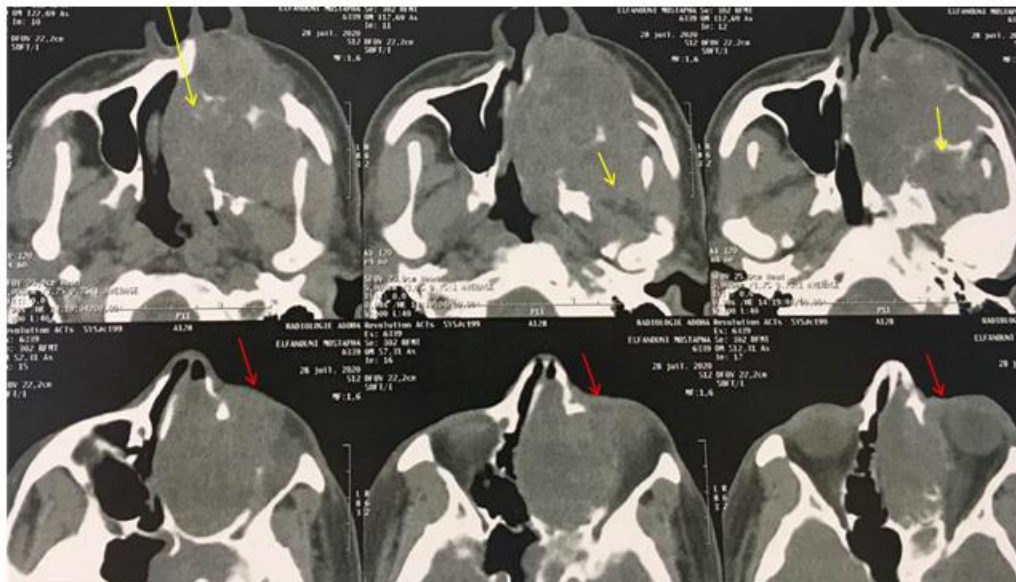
Axial CT scan showed voluminous mass of the left maxillary sinus
